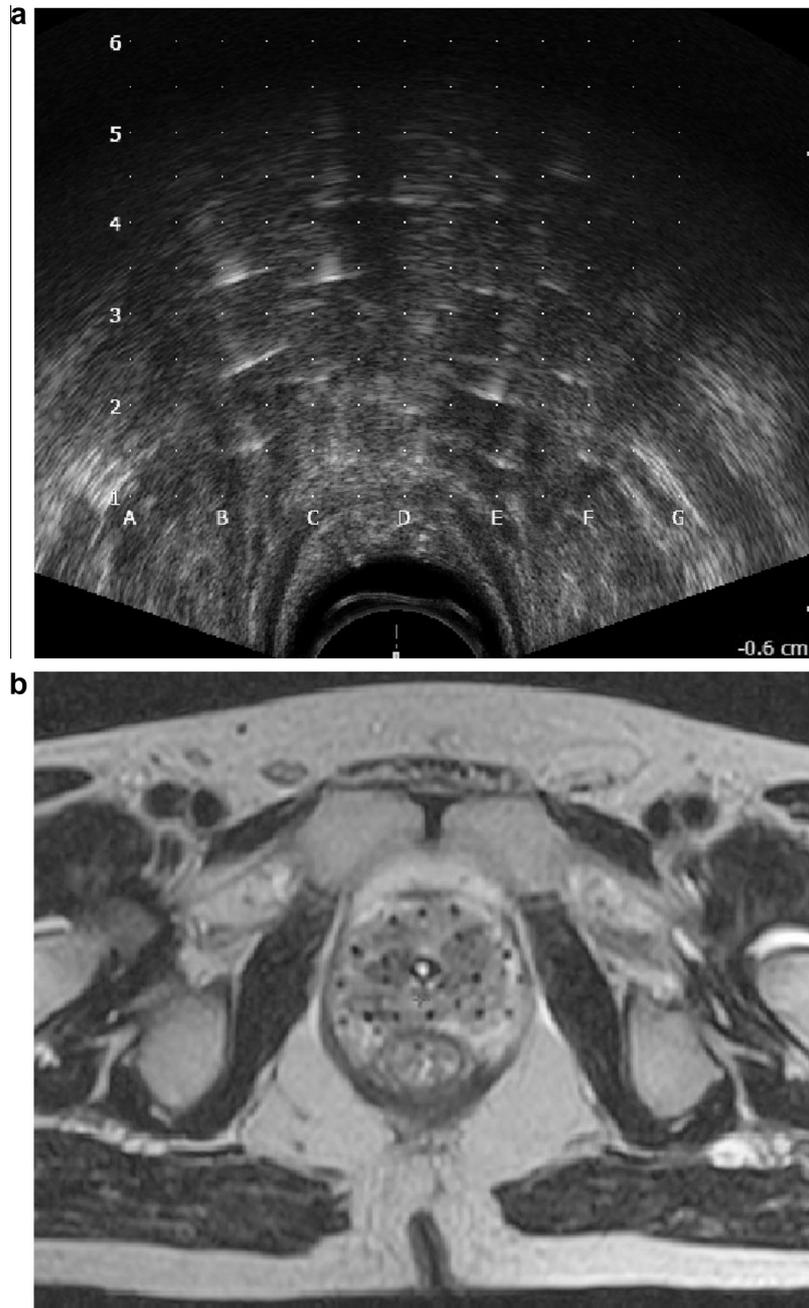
Transrectal ultrasound image (a) and T2 weighted MR image (b) of HDR implant.
